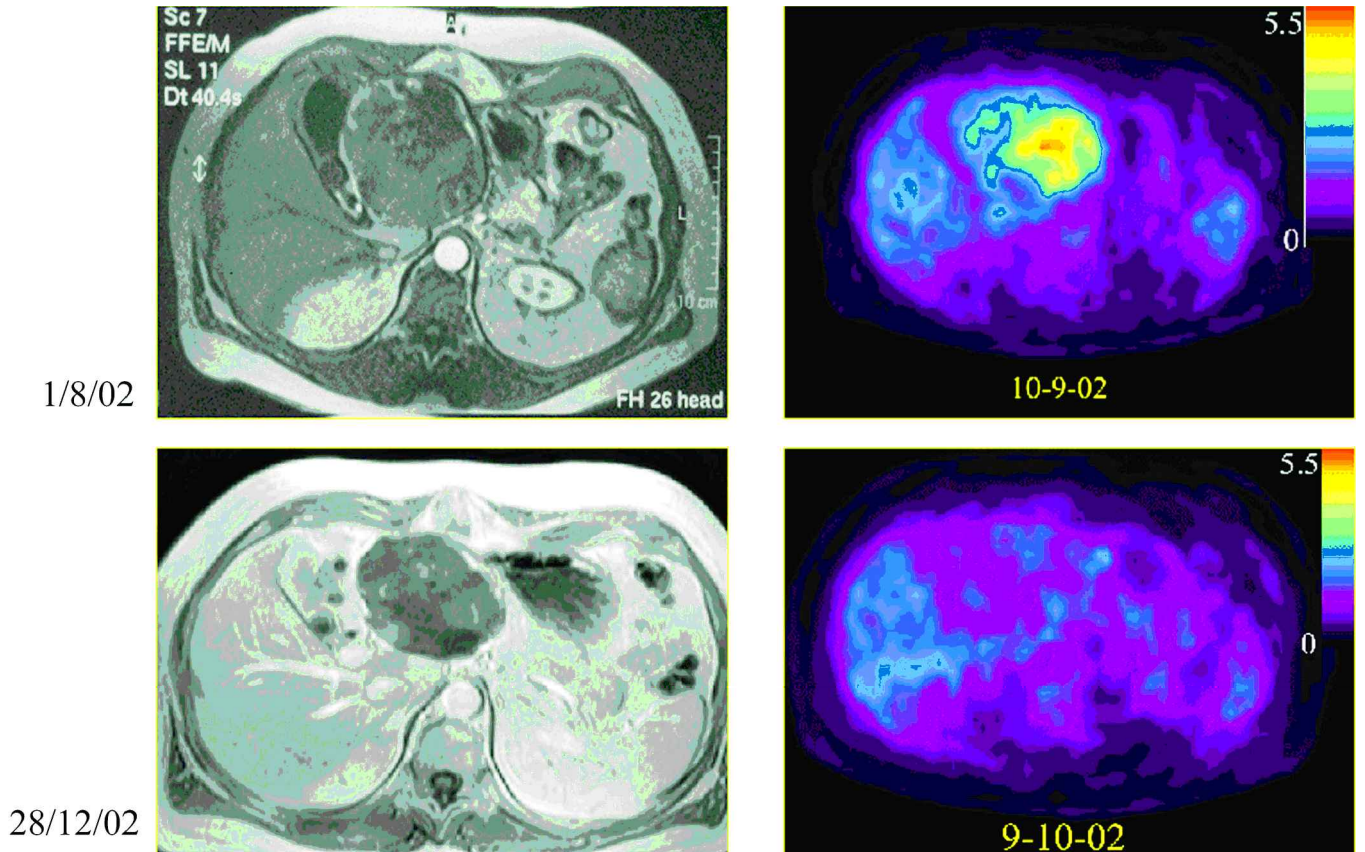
Positron emission tomography (PET) for monitoring Glivec tumour response: (left column) magnetic resonance images with intravenous contrast medium enhancement. A large liver mass (metastatic gastrointestinal stromal tumour) is little changed in size after nearly four months of imatinib (Glivec) treatment; (right column) specific uptake value (SUV) maps from 2-[F-18] fluoro-2-deoxy-D-glucose-PET scans at the same anatomic level. The tumour mass has become hypometabolic within four weeks of treatment.
